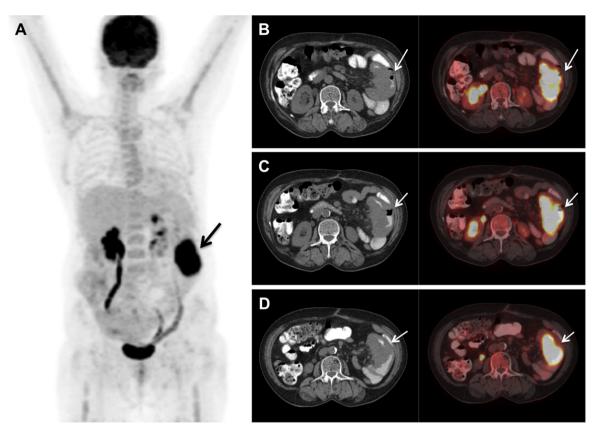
Positron emission tomography (PET) images taken before intestinal resection. (A) Maximum intensity projection; (B–D) Transaxial computed tomography (CT) and merged CT and PET images taken at different sequences. Images show 84 × 39-mm hypermetabolic, hypodense intestinal wall thickening (maximum standardized uptake value: 19.7) without any other distant metastasis (arrows).
